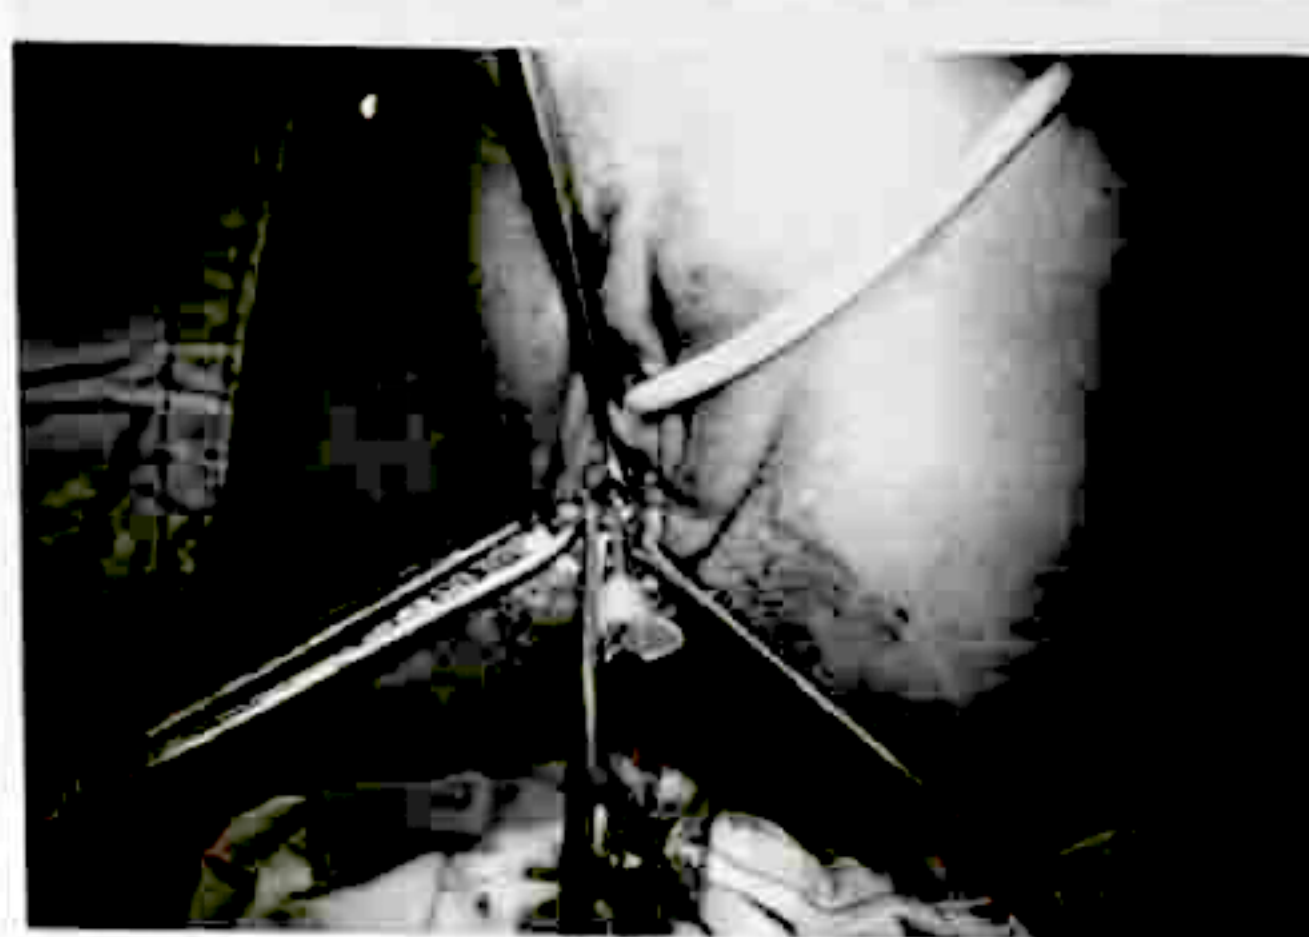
Ultrasound guided drainage of hematocolpos using a gauge 18 cannula.
